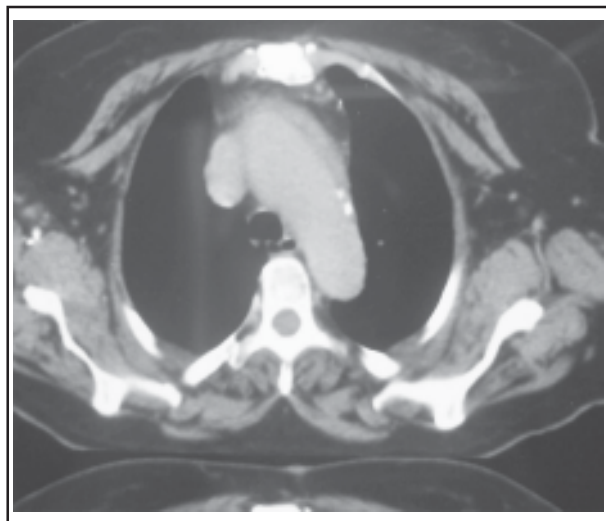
Type A dissection seen in Computed Tomography (CT) which is 7cm in diameter.
